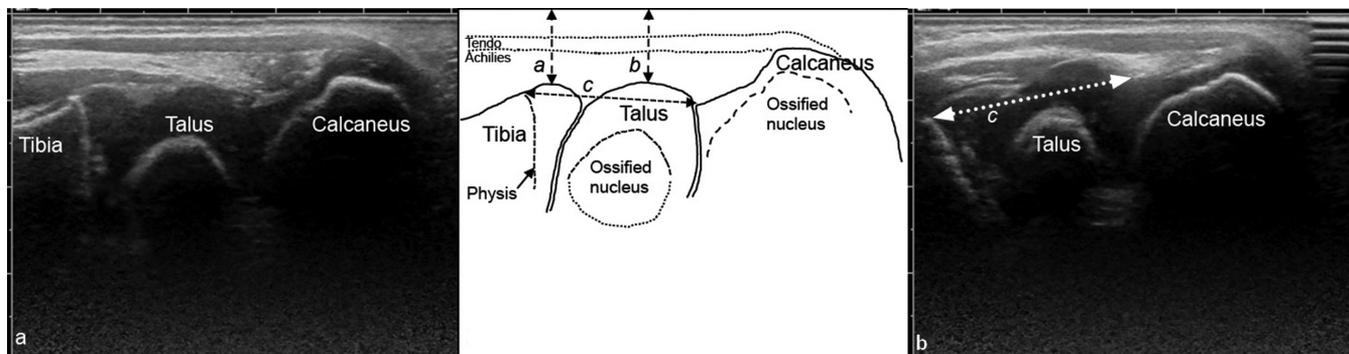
(a) Posterior ultrasonography scan of the left foot in neutral position in a 1.5-year-old boy with bilateral clubfeet (a skin – tibia distance, b skin – talus distance, c tibial physis – talocalcaneal joint distance) (Tib. phys. – TC); (b) the same foot as in (a) in dorsiflexion (c Tib. phys. – TC).
